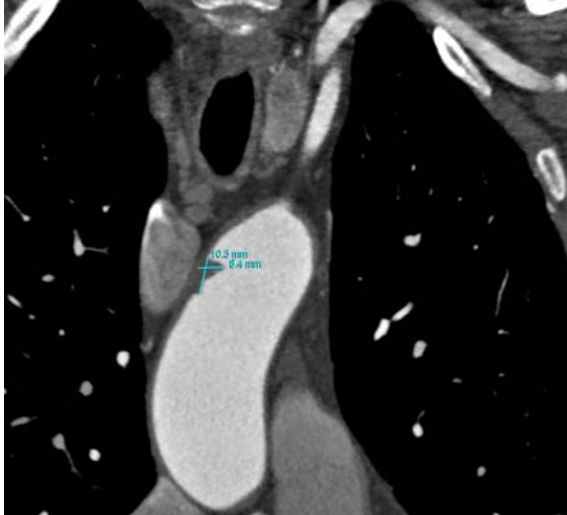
Remaining part of thrombus in ascending aorta on the control computed tomographic angiography, measuring 10.3x8.4 mm.
